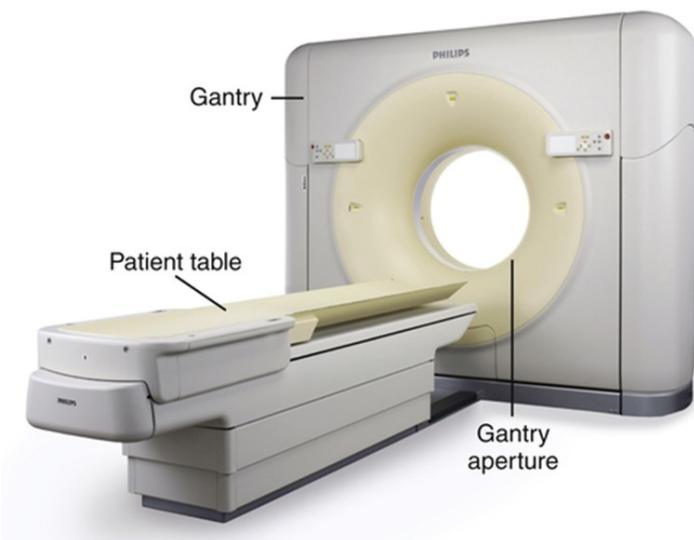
Model of a standard CT scanner. The patient will lie on the patient couch (patient table), which is led through the tunnel opening, or the X-ray tube gantry. The imaging and data collection occur within the opening, as this is where the X-ray tubes are located. During imaging, these tubes move around the patient to create an image.³⁶
